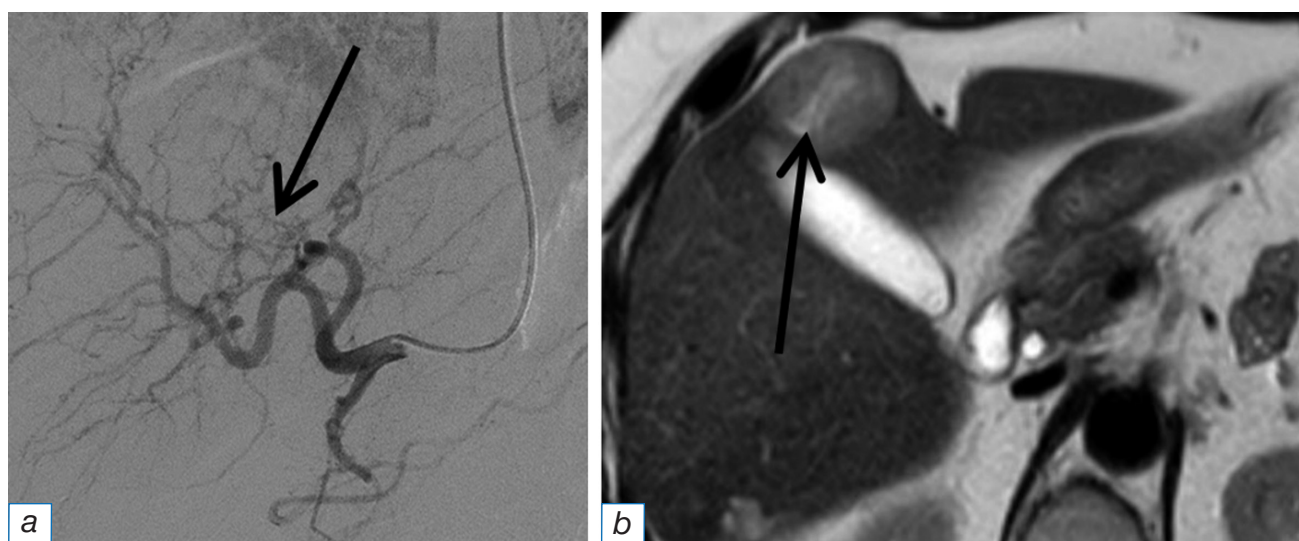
The same patient. Angiographic picture of another metastasis with a diameter of 3 cm (a): several thin recalibrated vessels (arrow) exiting in an atypical place; magnetic resonance imaging of the same metastasis (b): slit necrosis in the structure (arrow).
